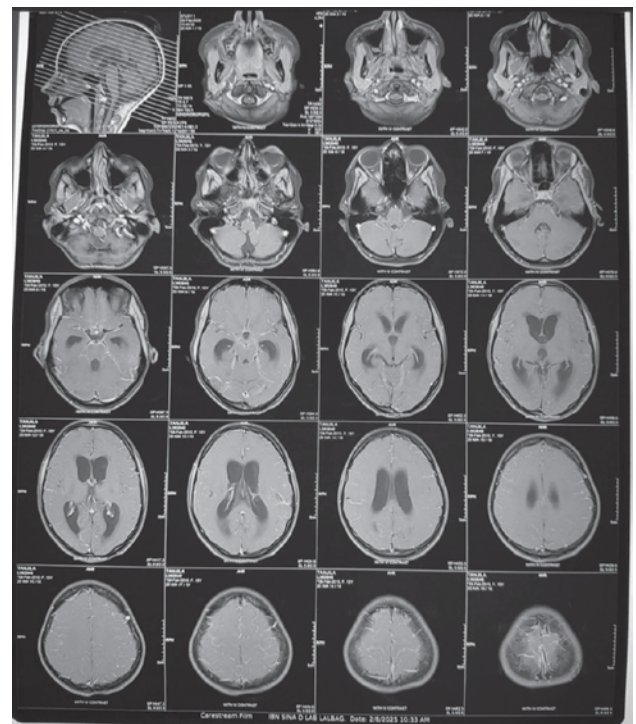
T1 sequence with contrast MRI shows no focal lesion in Brain
